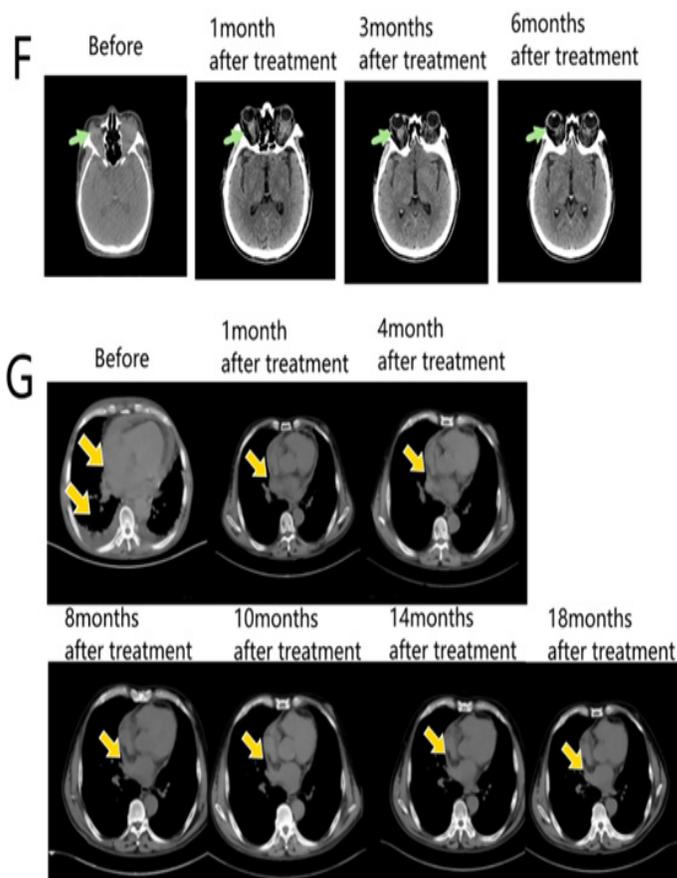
Follow up Computed tomography (CT) scans. F, CT scans showed the lesion became smaller after 1 months,3 months,6 months of targeted treatment. G, CT scans before and after treatment. The pre-treatment scan (left/top) shows a mediastinal mass with pericardial and pleural effusions. One month after treatment (middle/top), the effusions have resolved and the mass is smaller. The disease remained stable after 4,8,10,14,18 months follow-ups.
